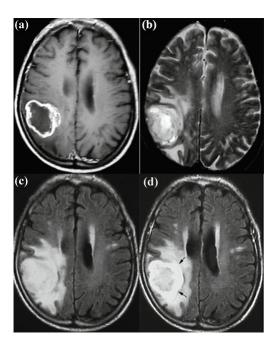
Four imaging modalities: (a) T1-weighted MRI; (b) T2-weighted MRI; (c) FLAIR; and (d) FLAIR with contrast enhancement $^{[5]}$.
